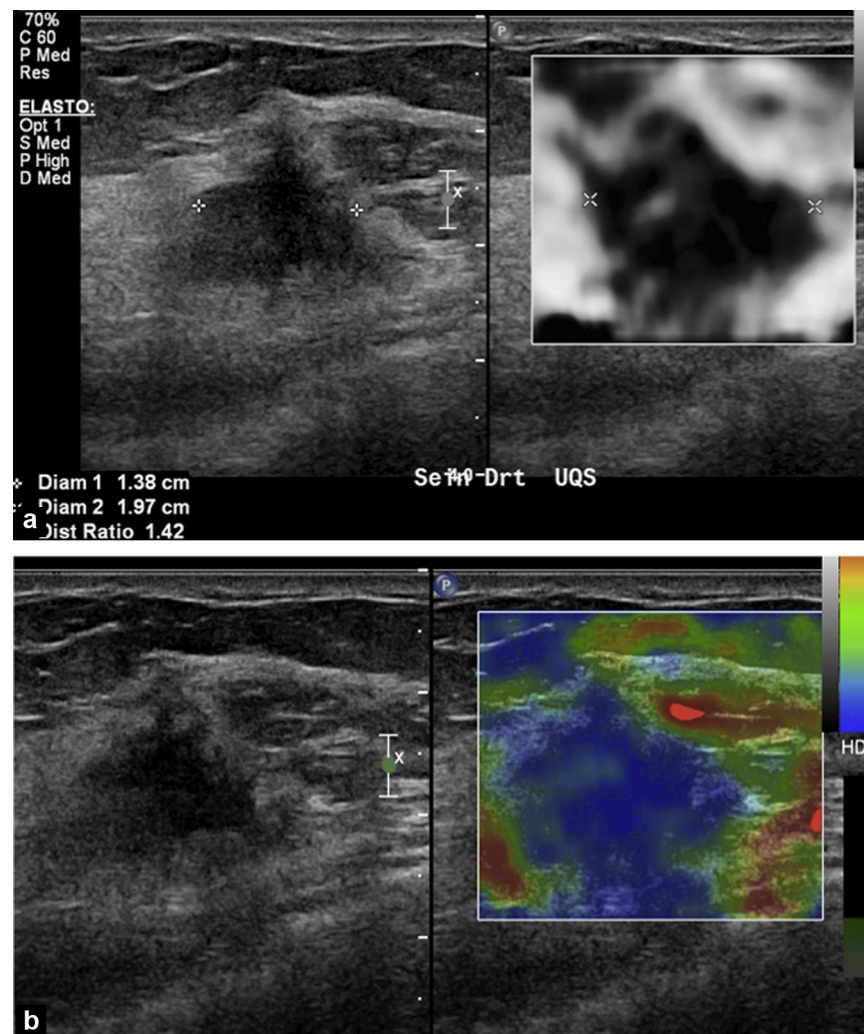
Infiltrative ductal carcinoma, free-hand elastography, black and white mode (a), colour mode (b) (Philips®). The size of the lesion on the black and white elastogram is larger than on B mode ultrasound: the lesion is very dark with irregular contours, which suggests a poorly deformable lesion as seen on malignant lesions. In colour mode, the lesion and adjacent tissues are blue, indicating a poorly deformable lesion. Biopsy confirmed a grade 2 infiltrative ductal carcinoma.
